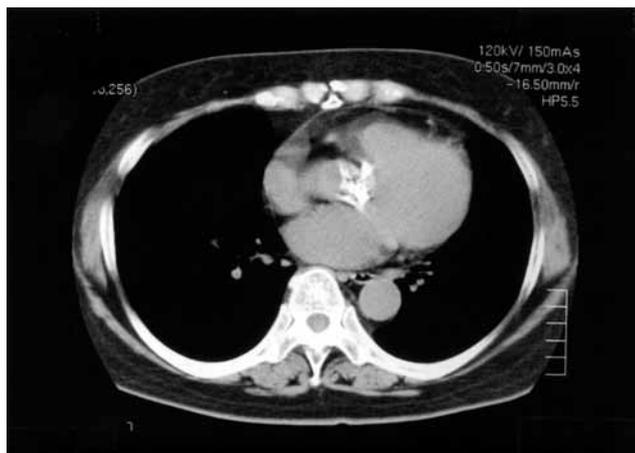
Chest CT before the surgery.
